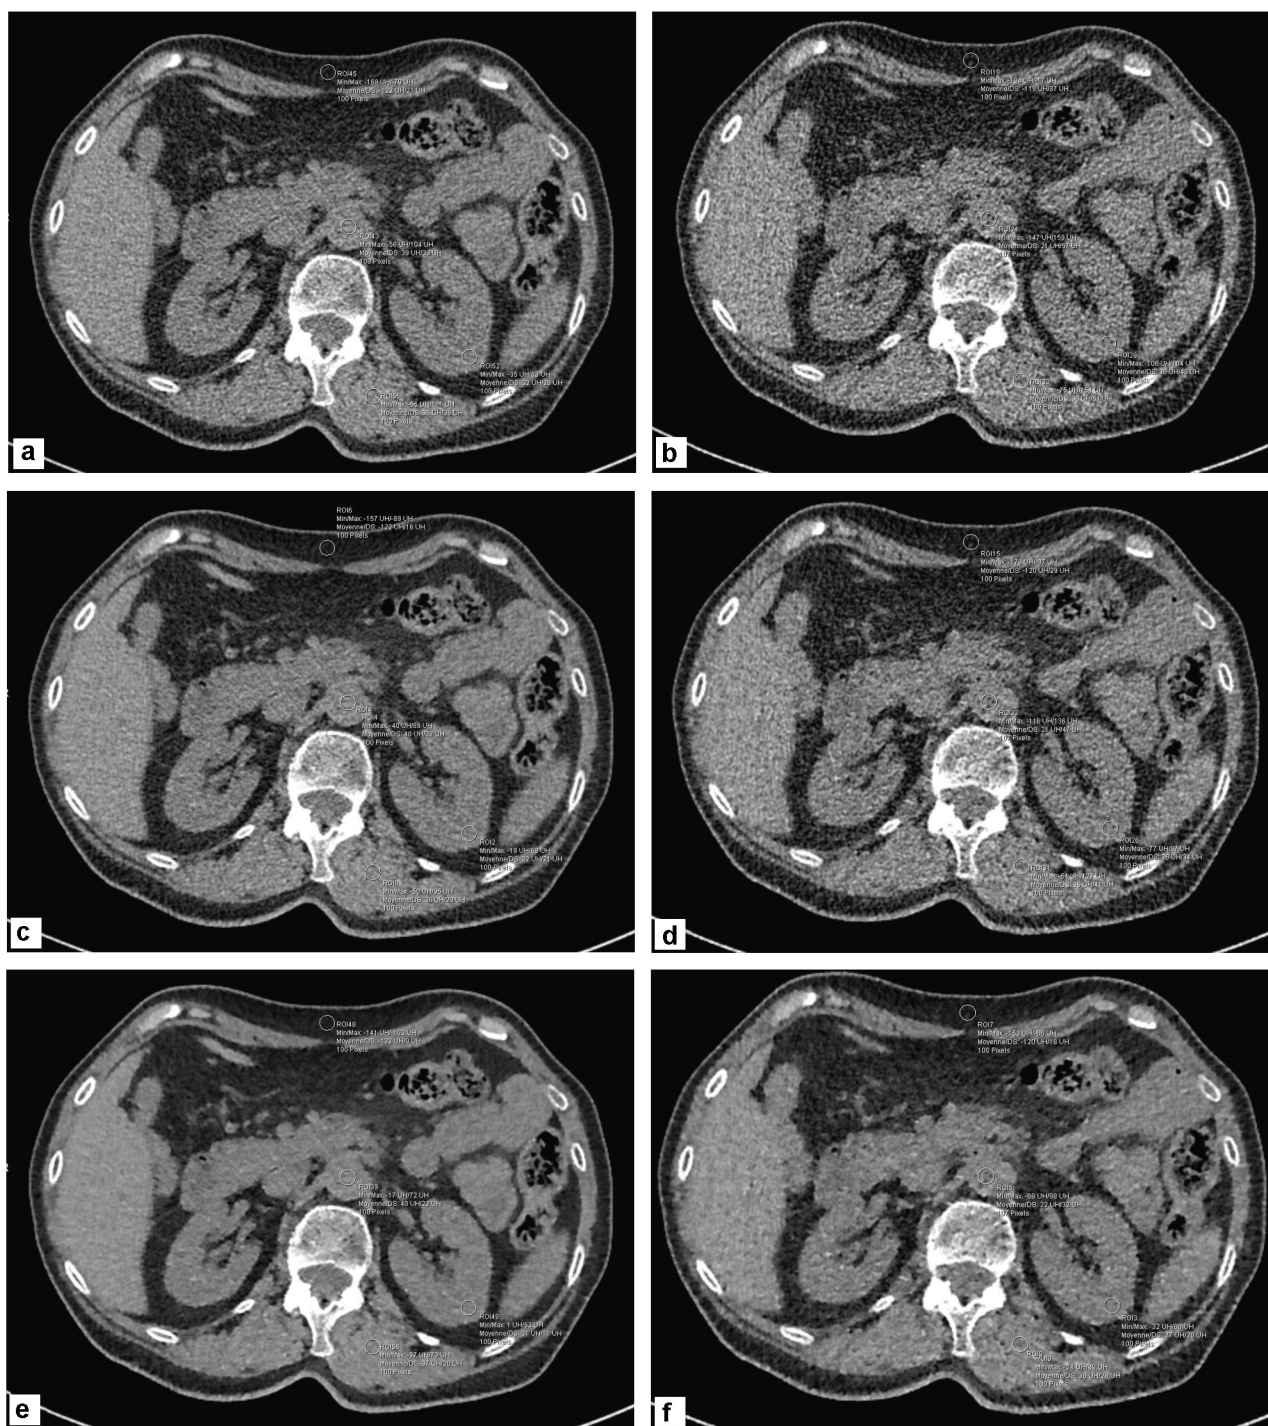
Transverse axial CT image in filtered back projection (FBP), S2 and S5 of a patient for the acquisitions with 30% (a, c, e) and 70% (b, d, f) dose reductions, with 4 regions of interest on the left kidney, the abdominal aorta, the fat and the psoas muscle. Visualization of the smoothing of the image with an increase in the Sinogram Affirmed Iterative Reconstruction (SAFIRE) level. The signal, noise, signal to noise ratio (SNR) and contrast to noise ratio (CNR) are equivalent between S2 at 30% (c) and S5 at 70% (f).
